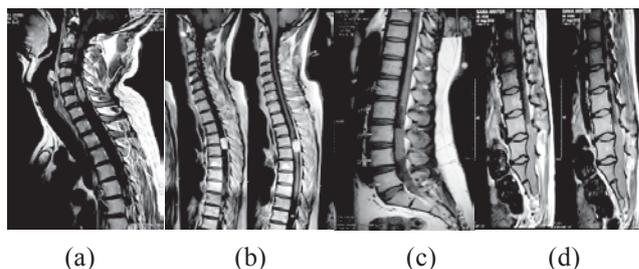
MRI of the spine showing spinal cord tumour at (a) cervical, (b) Dorsal, (c) Lumbar and (d) Lumbosacral region.
